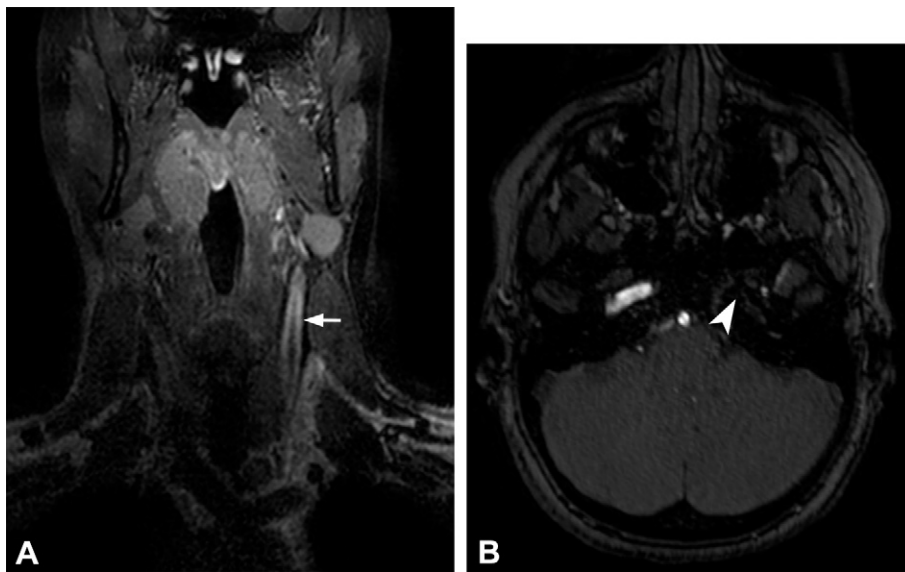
Takayasu arteritis subsequently diagnosed in a 15-year-old adolescent girl with episodic weakness. (A) Coronal contrast-enhanced T1W FS MR image of the vessel wall shows circumferential wall enhancement (arrow) of the common and internal carotid arteries. (B) Axial MR angiographic image reveals an absence of flow-related enhancement (arrowhead) in the left petrous internal carotid artery segment.
